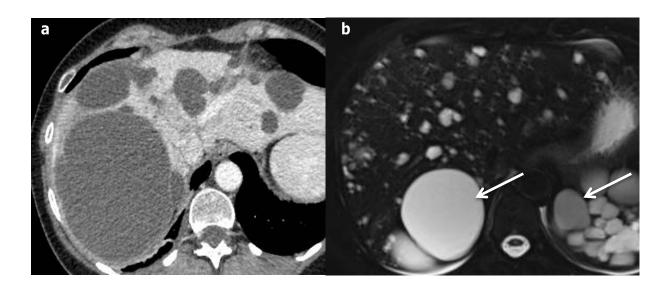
Autosomal polycystic kidney disease in a 38-year-old male patient. (a) Axial computed tomography at portal-venous-phase and (b) axial T2-weighted magnetic resonance imaging show several hepatic simple cysts and also numerous kidney cysts (arrows), with fluid signal (hypodense/hyperintense on T2).
